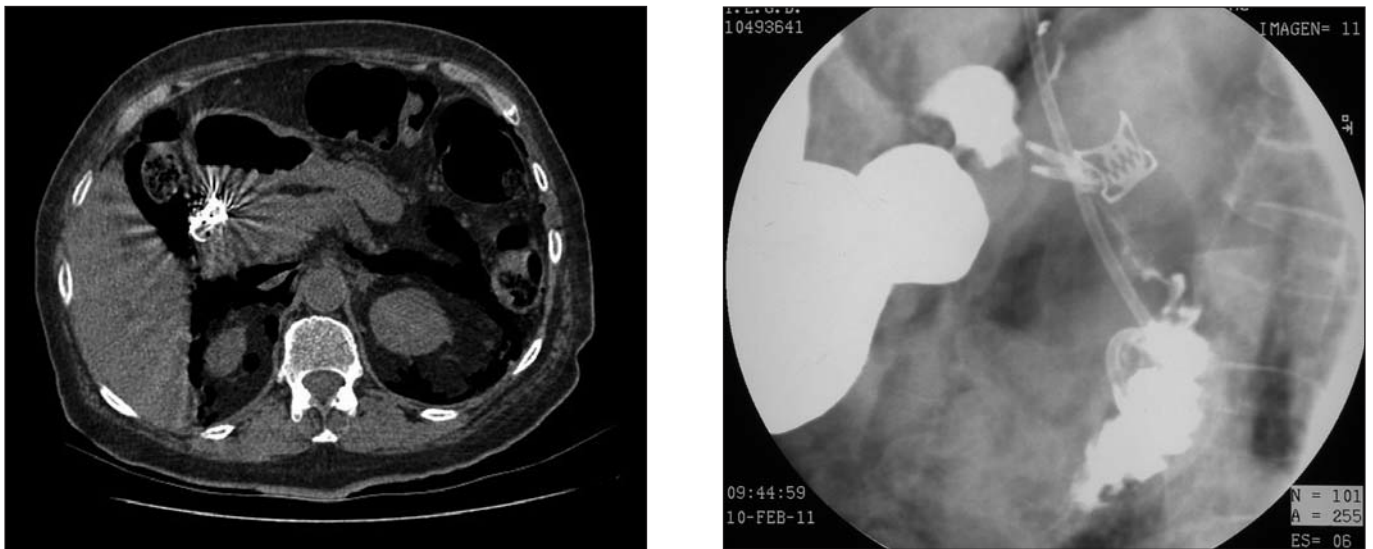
CT scan shows the OTSC in place, air in retroperitoneum, and no free intraperitoneal fluid (A). Gastrointestinal transit reveals complete sealing of duodenal perforation (B).
